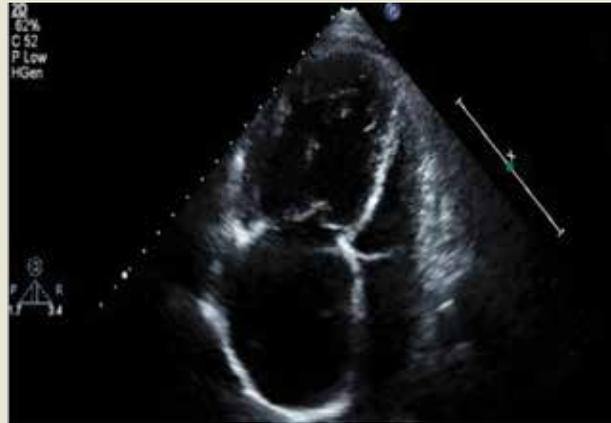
Echocardiography – apical 4-chamber view from the same patient. A grossly enlarged right ventricle and right atrium is shown, with bowing of the interventricular septum towards to the left ventricle, typical of severe pulmonary arterial hypertension.
